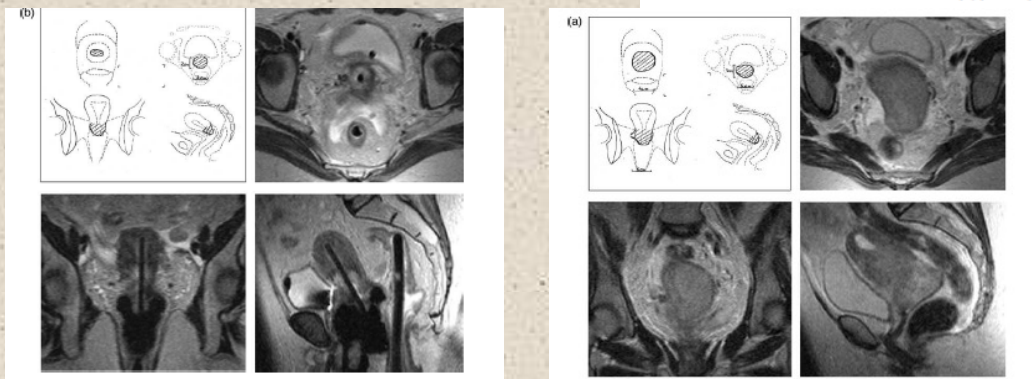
T2-weighted MRI of cervix carcinoma (sagittal view).
